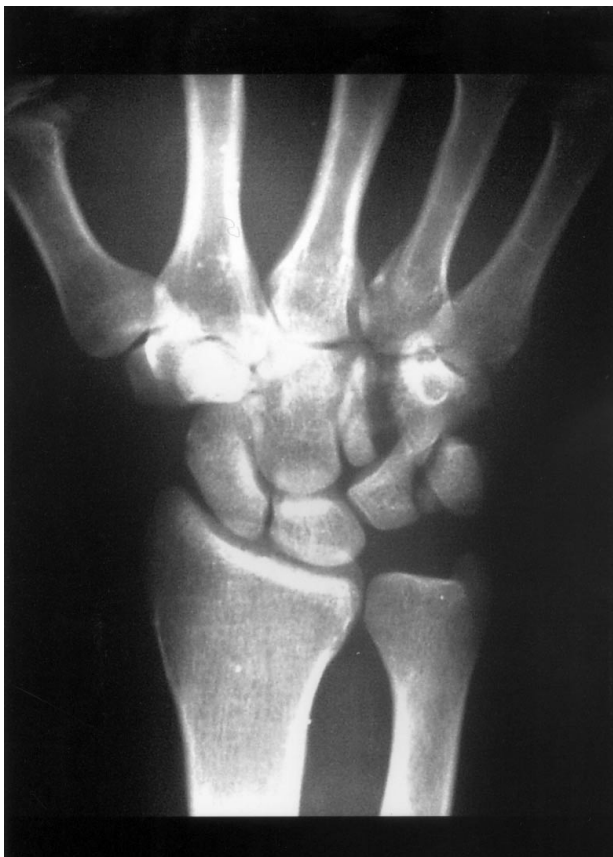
P-A X-ray of the patient's right wrist. Displaced fracture line is present on the body of the triquetrum and hamate. Separation between the third and fourth metacarpals is evident.
